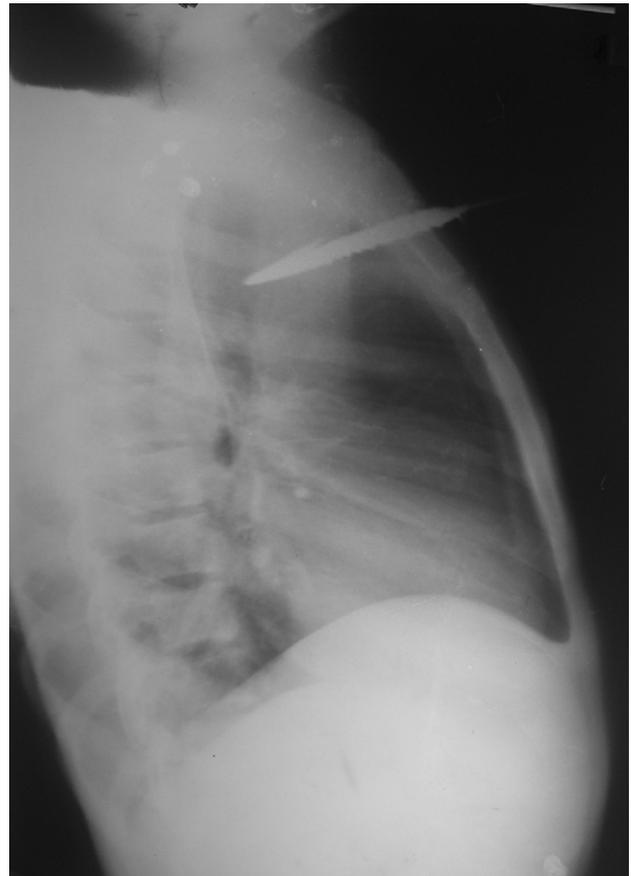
Right lateral roentgenogram of the chest showing the length of the metallic portion of the arrow.
